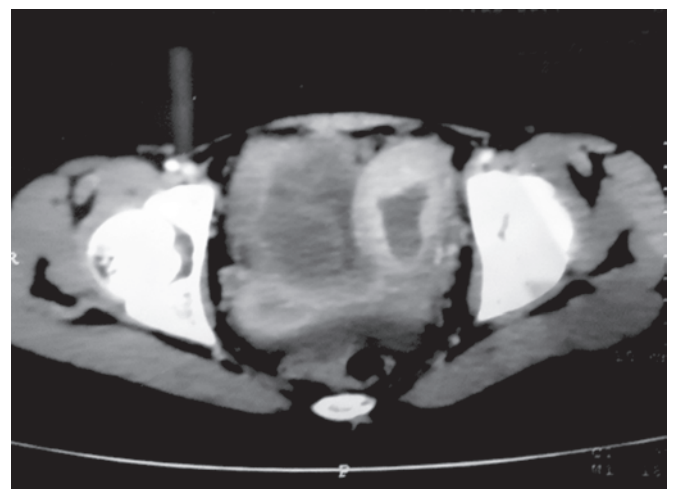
CT scan: Ill-defined multiloculated lesion in pelvic cavity and both ovaries are not seen separately
